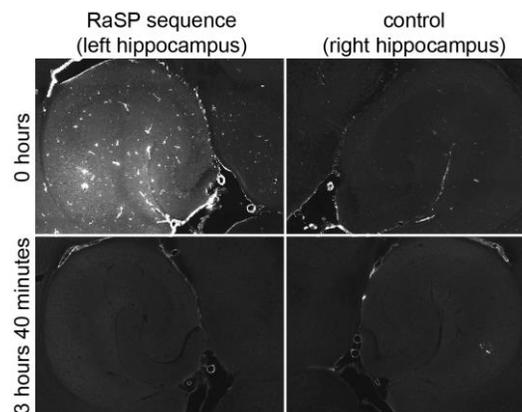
Our RaSP sequence produced a temporary (< 4h) alteration of BBB permeability. A fluorescently-tagged model drug (3-kDa dextran) was delivered across the BBB when systemically administered during ultrasound sonication, but not when injected 3h 40min after. [preliminary results]
